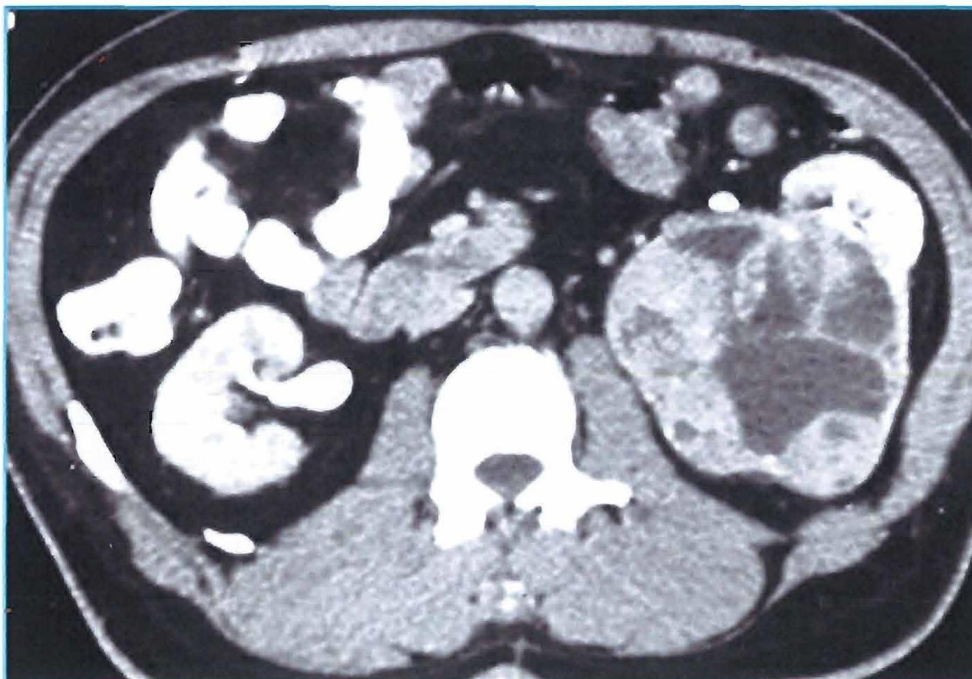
CT shows cystic masses with multiple thick septae and large mural nodule- Multilocular Wilms.
